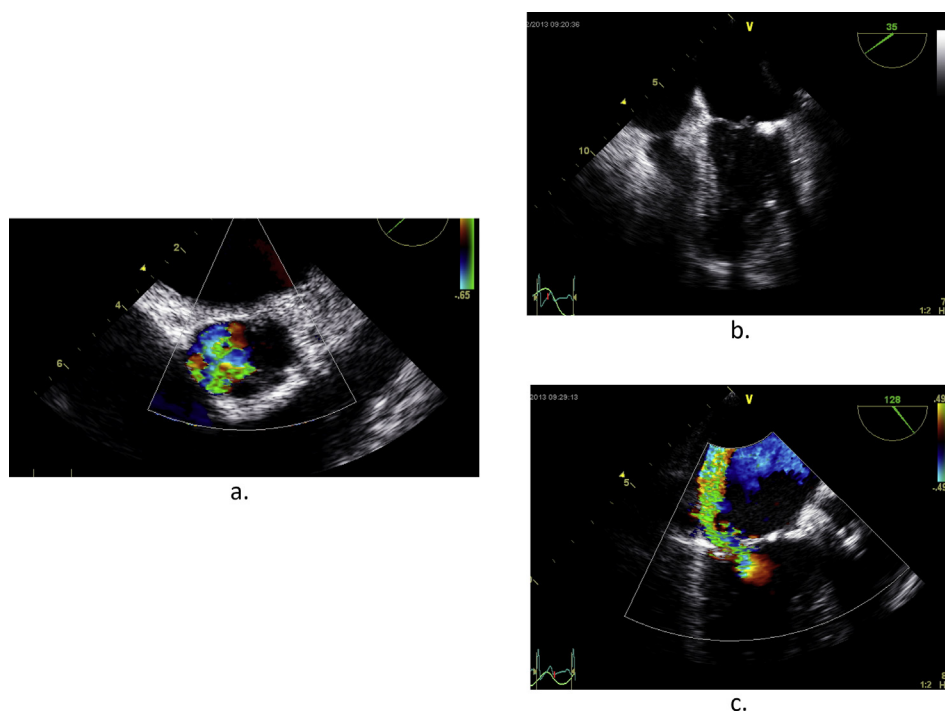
On-table preoperative transesophageal echocardiogram showing: a. the aortic valve in the short-axis view demonstrating the severe AI originating from the NCC. b. the prolapsing anterior mitral valve leaflet. c. the resulting severe posteriorly directed jet on color Doppler flow
